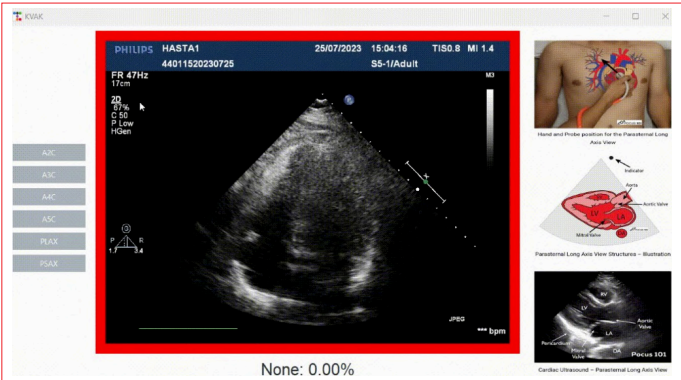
A4C measurement to improve visualization and user-friendliness, we developed a dedicated application for our model. In this application, the user can select the desired echocardiographic view using the buttons on the left panel. On the right side, we included reference images to assist students while reviewing the selected view. The central area displays the real-time echocardiographic image. A guiding frame appears around the image: green if the correct view is approached, and red if the current view is far from the target, helping guide the user toward the correct position. At the bottom of the interface, the model's prediction and its confidence percentage are displayed. The video format of the file could not be loaded. A measurement video is available. It can be sent upon request.
